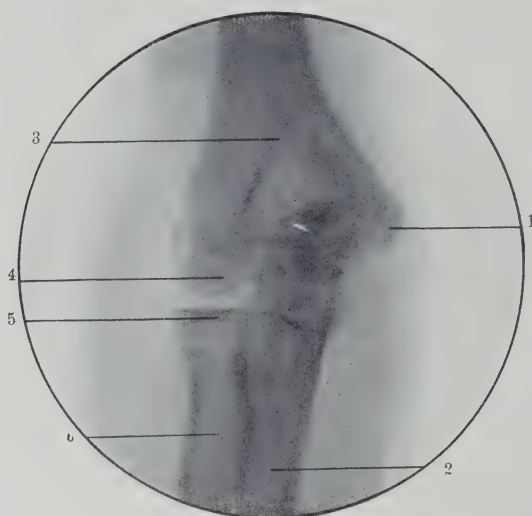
Radiograph Showing Vertical View of Elbow at Thirteen Years. 1, Trochlea; 2, ulna; 3, humerus; 4, capitellum; 5, upper epiphysis of radius; 6, radius. (Original.)
